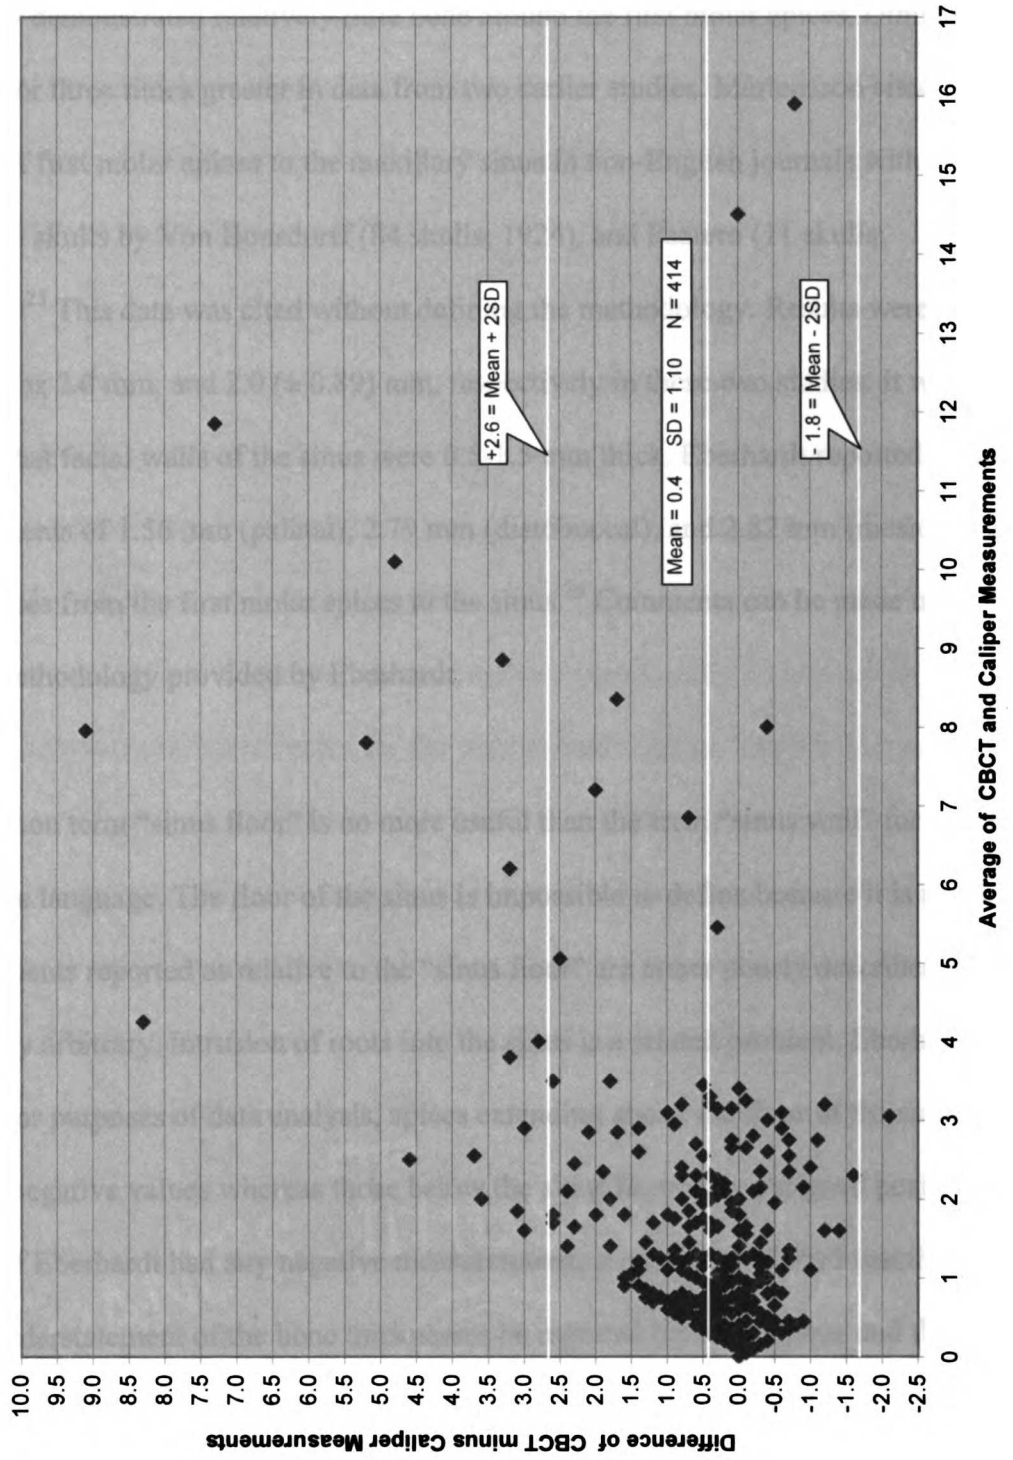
Bland-Altman curve of CBCT and caliper measurements.
